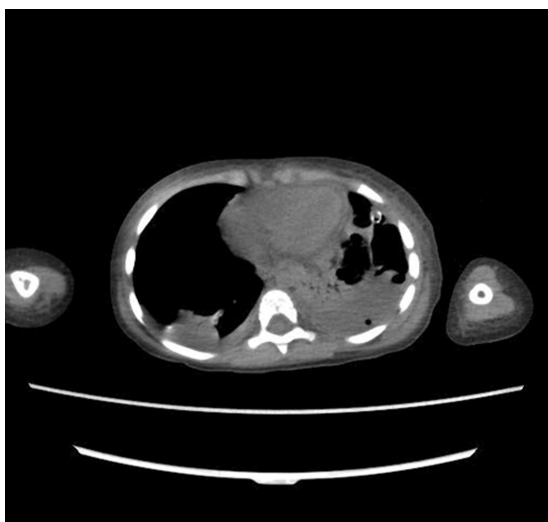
CT-scan Chest: Left-sided pyopneumothorax with collapse/consolidation of underlying left lung, and also right lung base collapse.
